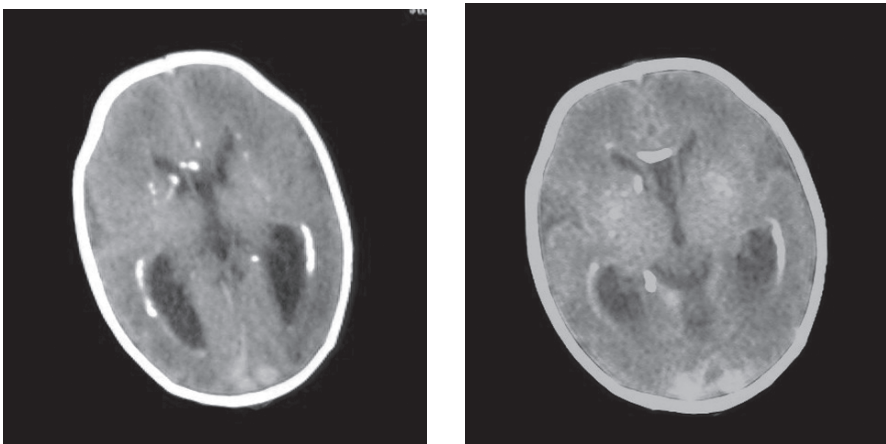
Head CT scan, axial images, of two patients with congenital CMV demonstrates periventricular calcifications and dilated lateral ventricles.
